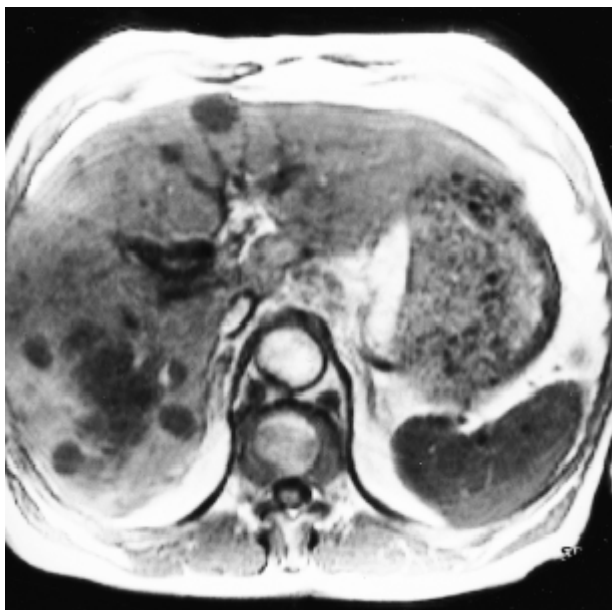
Multiple hepatic metastases of EMPD in patient 2. Gradient-echo T1-weighted MRI showing multiple lesion of low intensity in both lobes of the liver.
